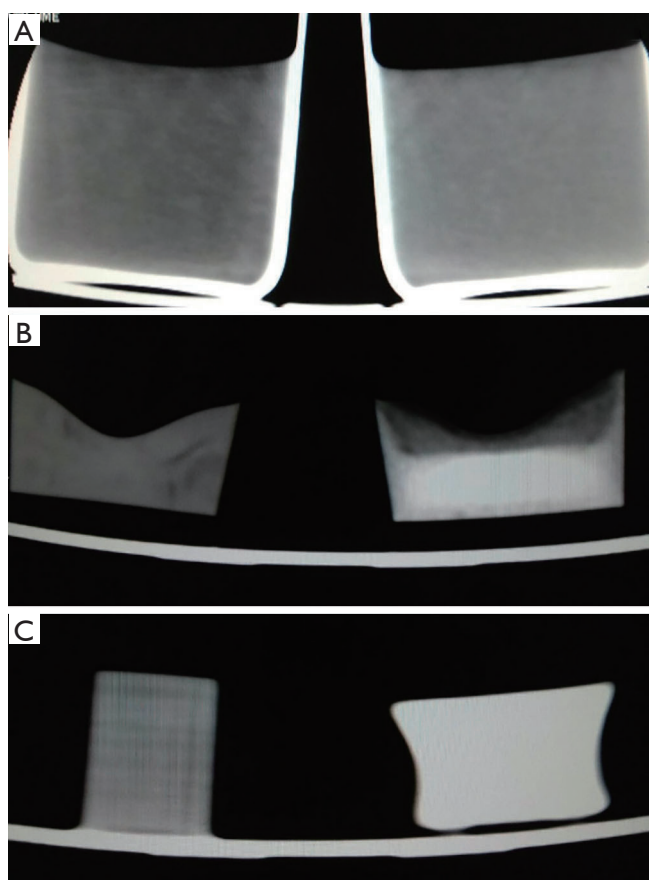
CT images of the unmodified materials (left column) and improved materials (right column). (A) Agarose, (B) wax and (C) printed materials.
